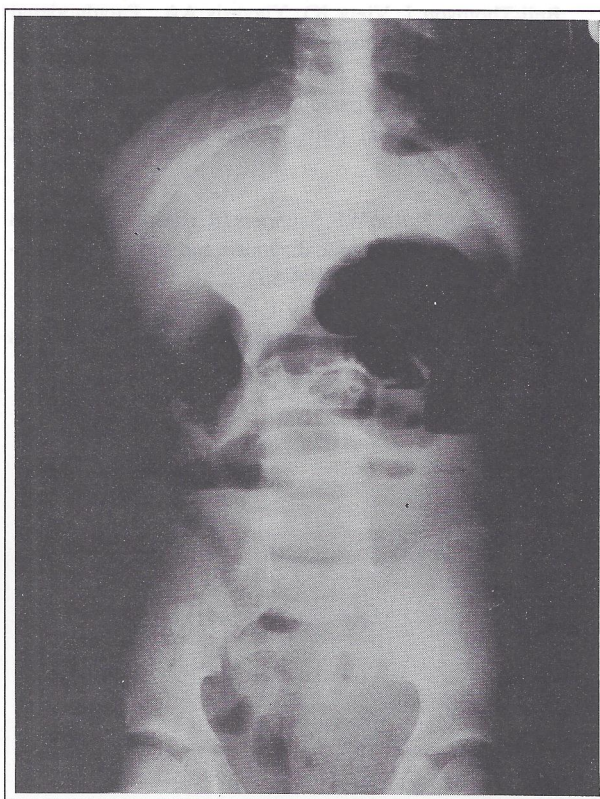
Plain erect X-ray of the abdomen showing dilated loops of small intestine with multiple air fluid levels. The dilated loops of bowel are confined more to the left upper quadrant of the abdomen.
